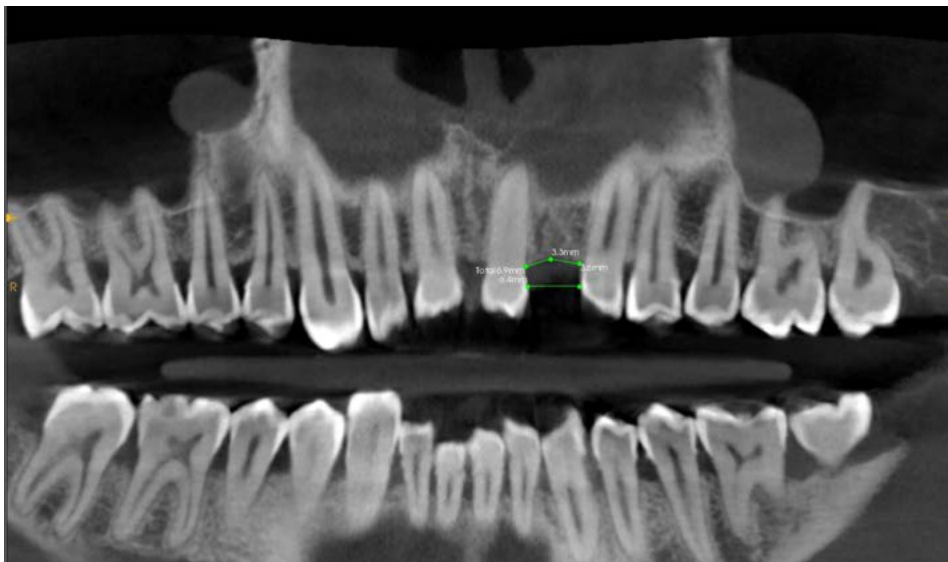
OPG derived from arch view and CBCT scan
